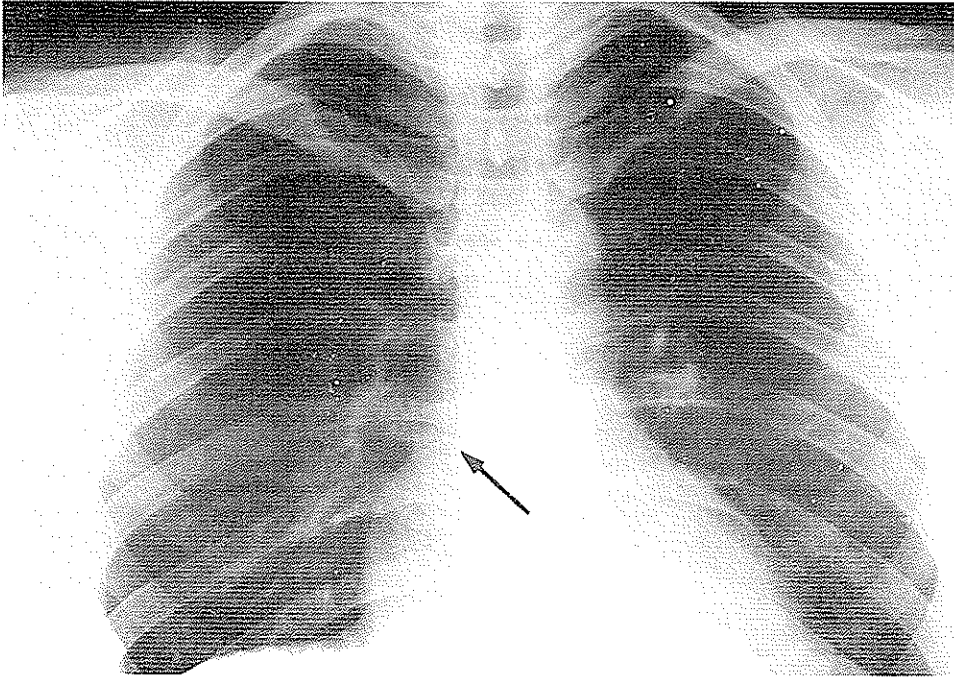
Radiograph, revealing a small dot suspected to be catheter knotting.
